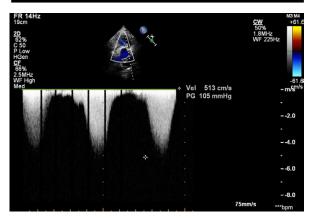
Preoperative 2-dimensional echocardiogram (color-flow Doppler mode) shows severe regurgitation of the atrioventricular valve and low-lying pulmonary stenosis with a 105-mmHg pressure gradient.
